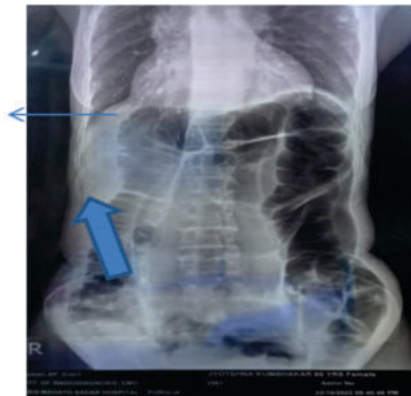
X-ray showing dilated sigmoid (thin arrow) with coil of ileum (thick arrow)
